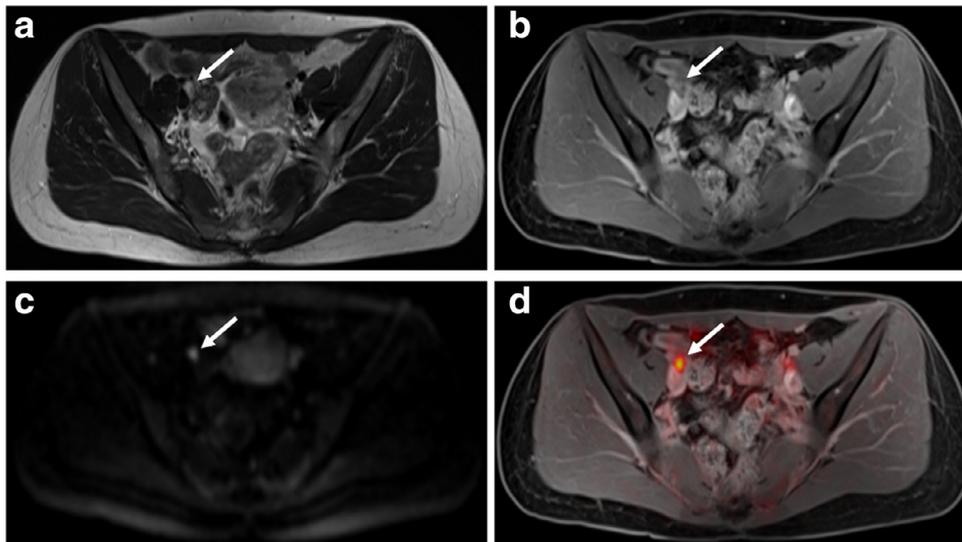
Images of a 59-year-old patient with primary cervical cancer and an ^{18}F -FDG-PET positive lymph node metastasis in the right hemipelvis. MR images (a, T2w; b, contrast-enhanced T1w) show a nonenlarged, hence morphologically nonsuspicious lymph node adjacent to the right iliac vessels. The correct diagnosis could be made based on its restricted diffusivity (c, DWI) and pathologically increased glucose metabolism (d, PET/MR).
